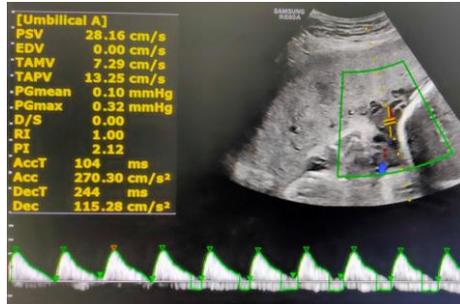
UA Doppler showing absent diastolic flow.
